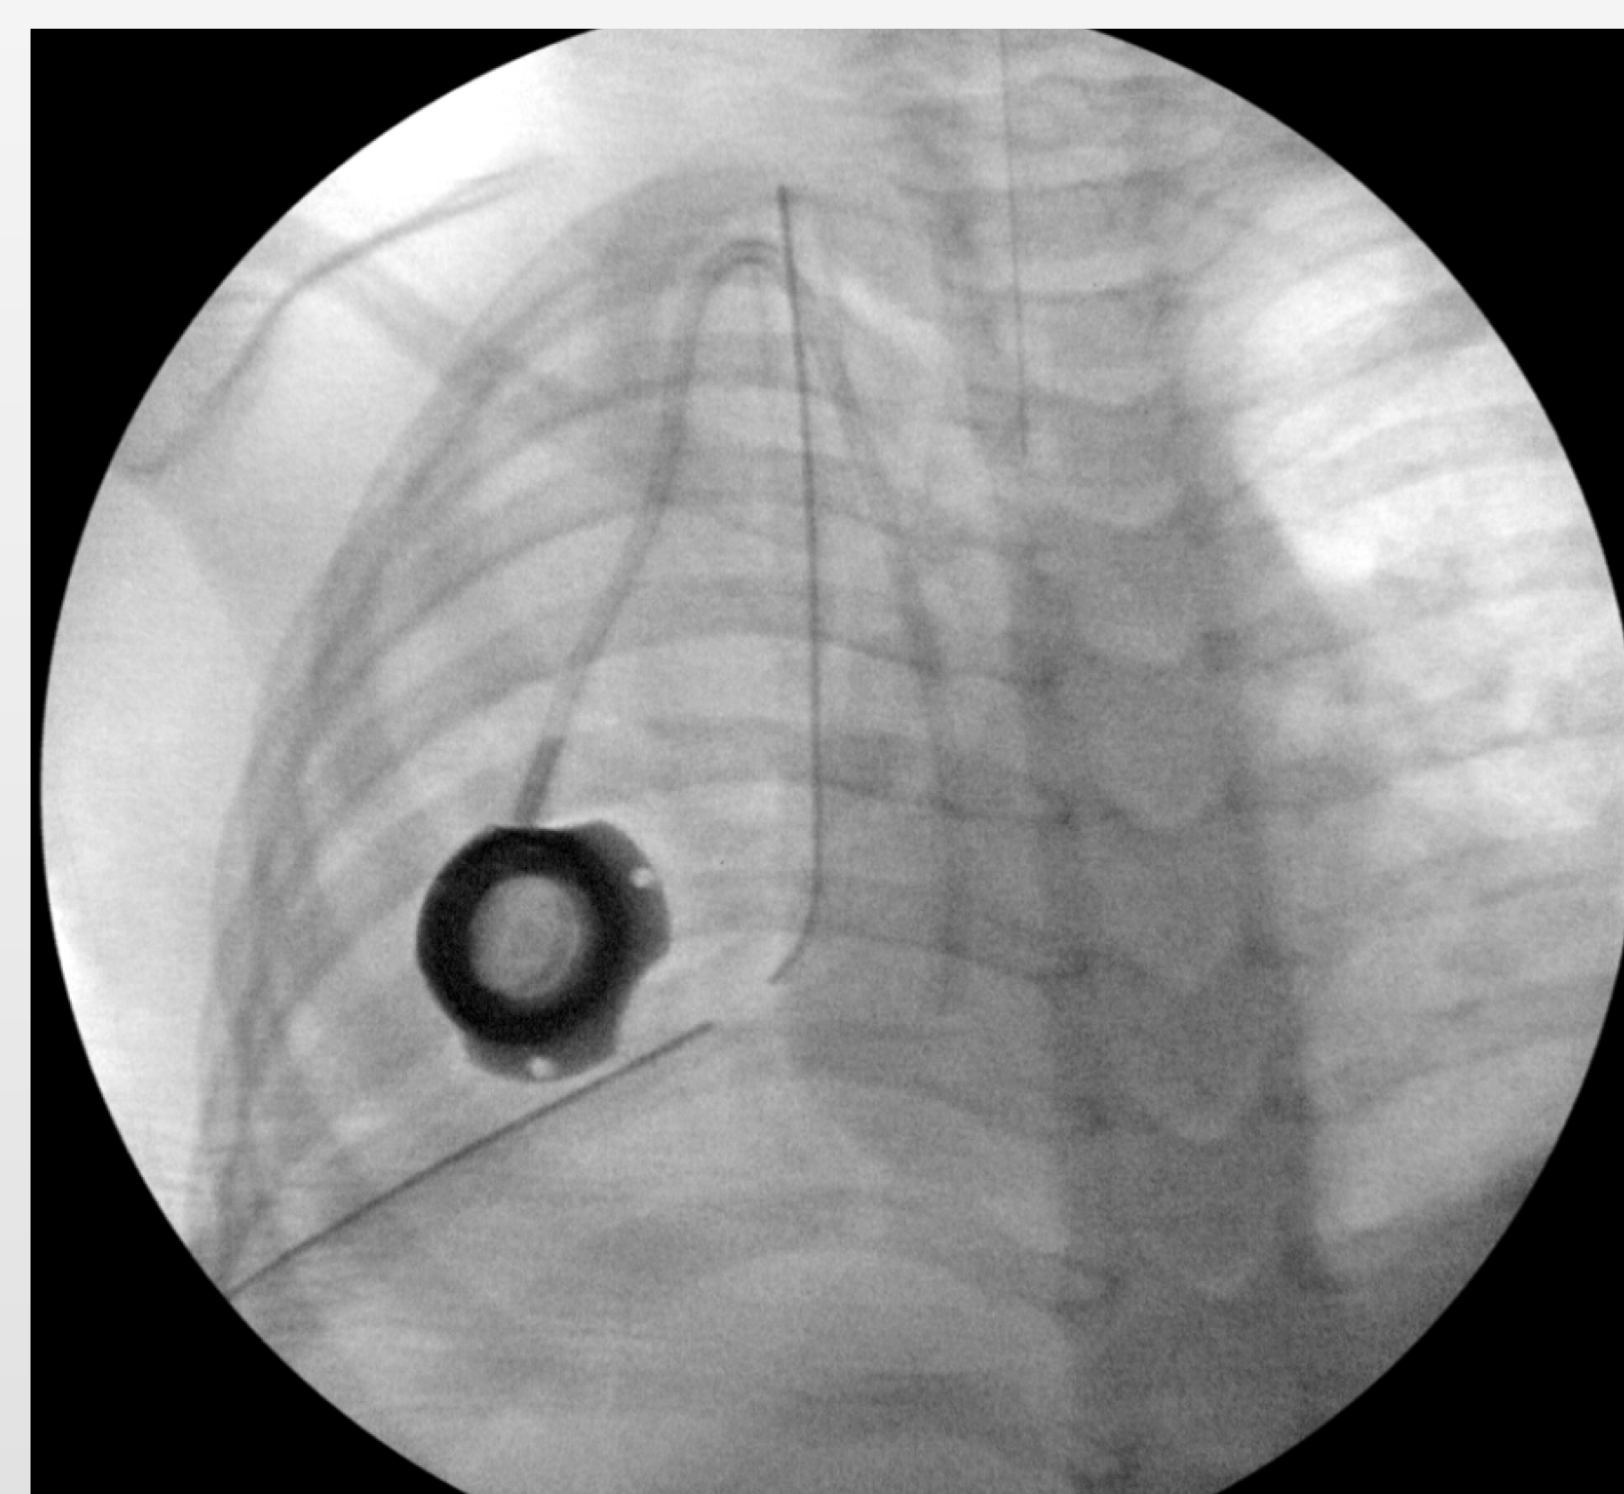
X-Ray after second port placed without significant mediastinal shift
